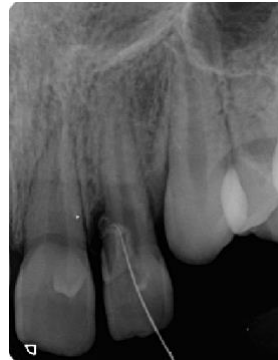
The length determination radiography of invaginated root canal.
